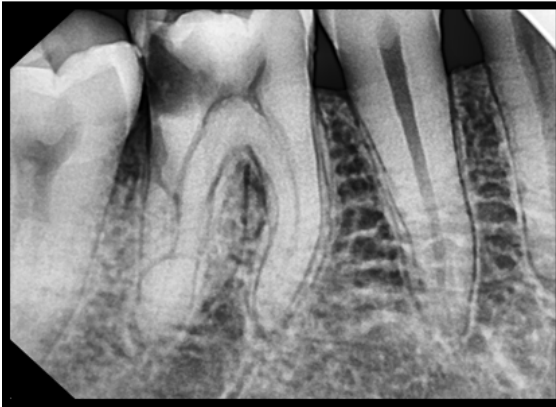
Preoperative radiograph of #46 showing deep distal caries exposing the pulp.
